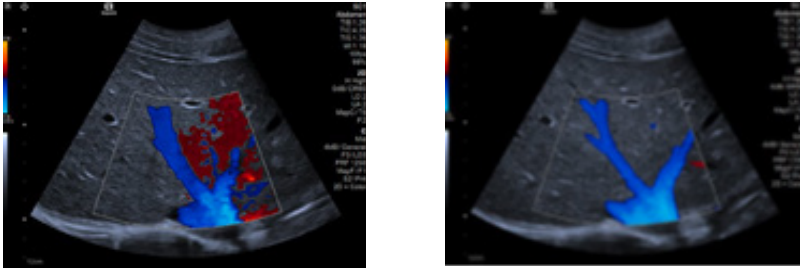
Conventional colour Doppler image with motion artifacts (left). Same patient (right) with Auto Flash Artifact Suppression technology.
